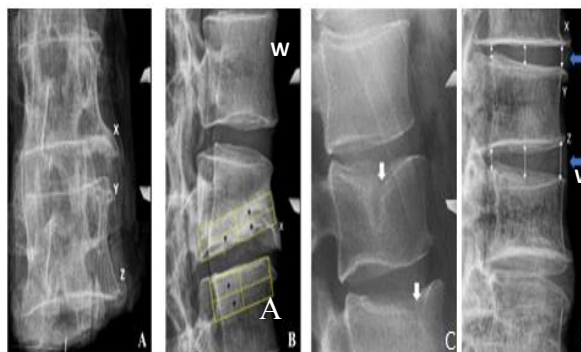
Anteroposterior (A) and lateral (B, C & D) views of radiographs showing different features of radiological degeneration. A: Osteophytes can be seen as small bony projections protruding from the corners of the vertebral bodies at X, Y and Z sites. B: Lateral view showing osteophytes along with sclerosis as black asterisks inside the yellow boxes. C: Schmorl's nodes (white arrows). D: Osteophytes (X, Y and Z) and variations in the disc space between consecutive spinal levels (blue arrows) at anterior, middle and posterior part (white arrows) of the intervertebral space can be seen.
